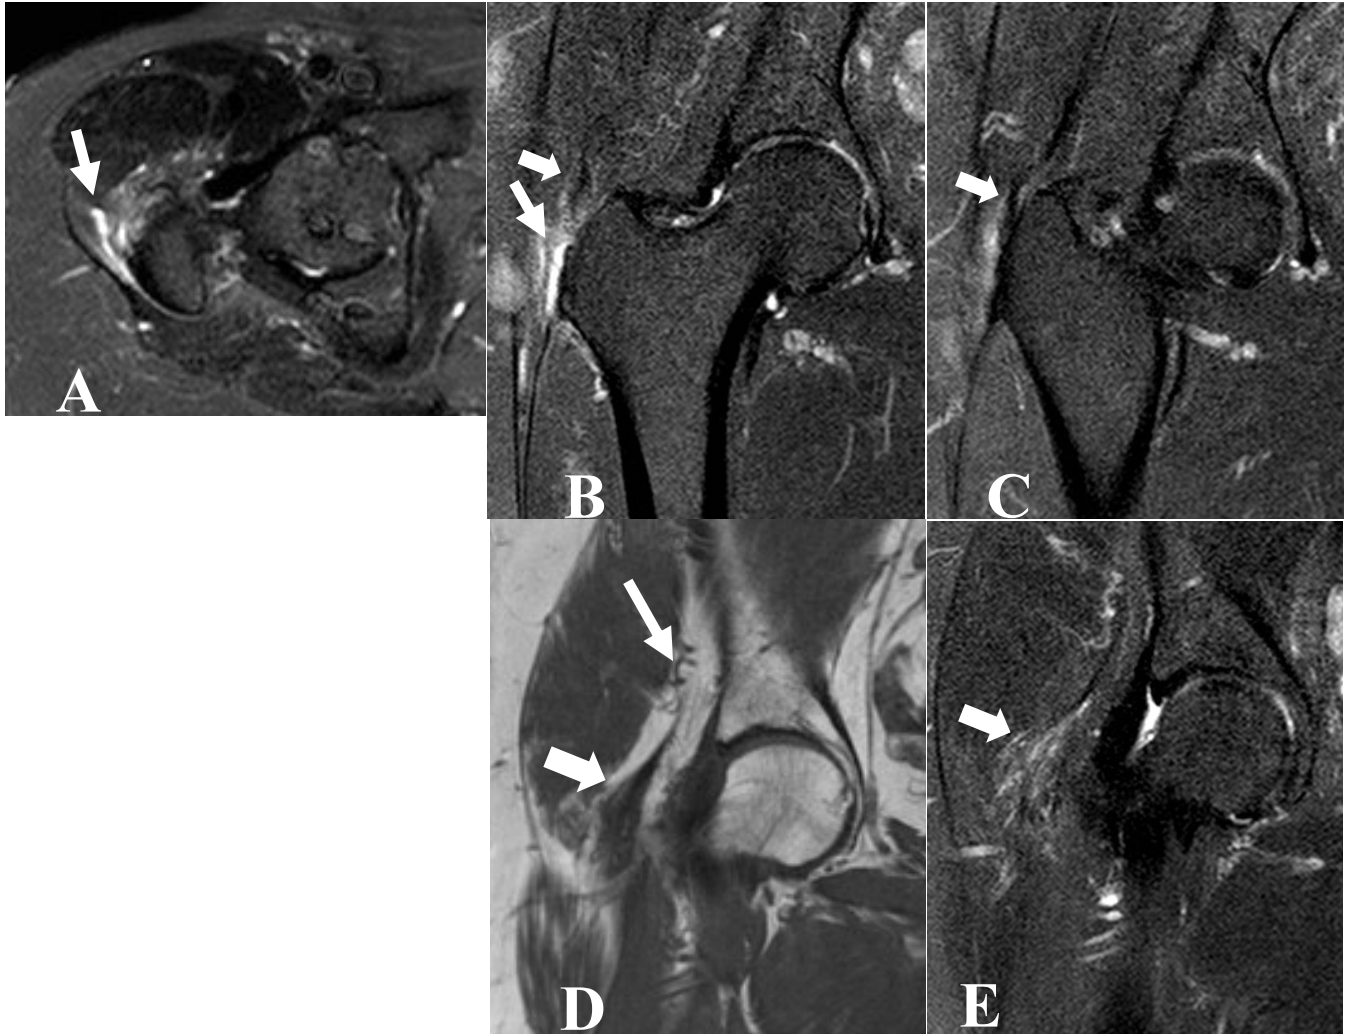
Conventional MRI in a 67-year-old woman with right hip chronic gluteal tendinopathy identified by both readers as a patient. Axial STIR image shows fluid distension of the greater trochanteric bursa (arrow). Both readers identified this finding as a grade 2 lesion (bursitis). b Coronal fat-suppressed T2-weighted image demonstrates hyperintense signal at the lateral facet of the greater trochanter (thin arrow) and an irregular, partially-retracted lateral gluteus medius tendon (thick arrow). c A more posterior image shows the tendon attaching to the facet (thick arrow). One reader diagnosed a lateral gluteus medius grade 1 lesion (tendinosis) whereas the other reader diagnosed a grade 3 (complete tear) lesion. d Coronal T1-weighted image depicts fatty infiltration of the gluteus minimus muscle (thin arrow) identified as a grade 4 lesion (more fat than muscle) by both readers. The gluteus minimus tendon (thick arrow) shows increased signal intensity and thickening. e Corresponding coronal fat-suppressed T2-weighted image demonstrates increased signal in the area of the gluteus minimus tendon (thick arrow). One reader diagnosed a gluteus minimus grade 1 lesion (tendinosis) whereas the other reader reported a grade 2 lesion (partial tear).
